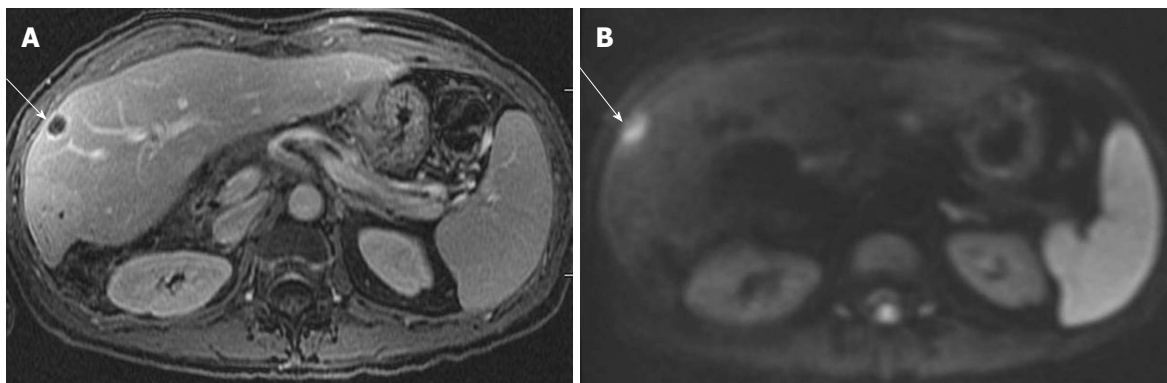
Liver abscess in a patient with Crohn disease. A: Axial post contrast T1-weighted gradient recalled-echo; B: Diffusion-weighted image image. Rim enhancing lesion is seen in the right hepatic lobe, with corresponding bright lesion on diffusion weighted image. The apparent diffusion coefficient map (not shown) showed corresponding hypointense lesion suggesting true impeded diffusion. This should not be confused with liver tumors which may also show impeded diffusion. Appropriate clinical settings should suggest the diagnosis. The lesion resolved with antibiotics on follow-up.
